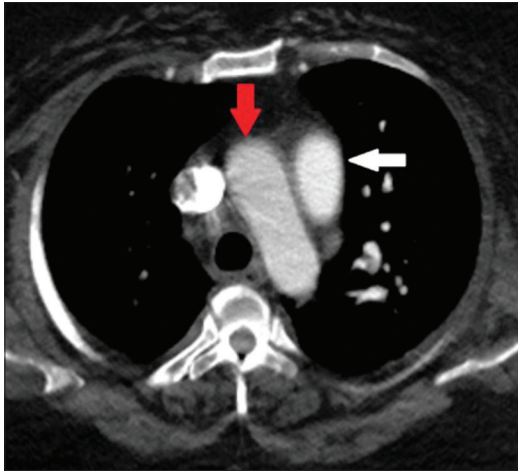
Axial computed tomography with contrast of chest shows the egg (white arrow) and banana (red arrow) sign indicative of severe pulmonary arterial hypertension
